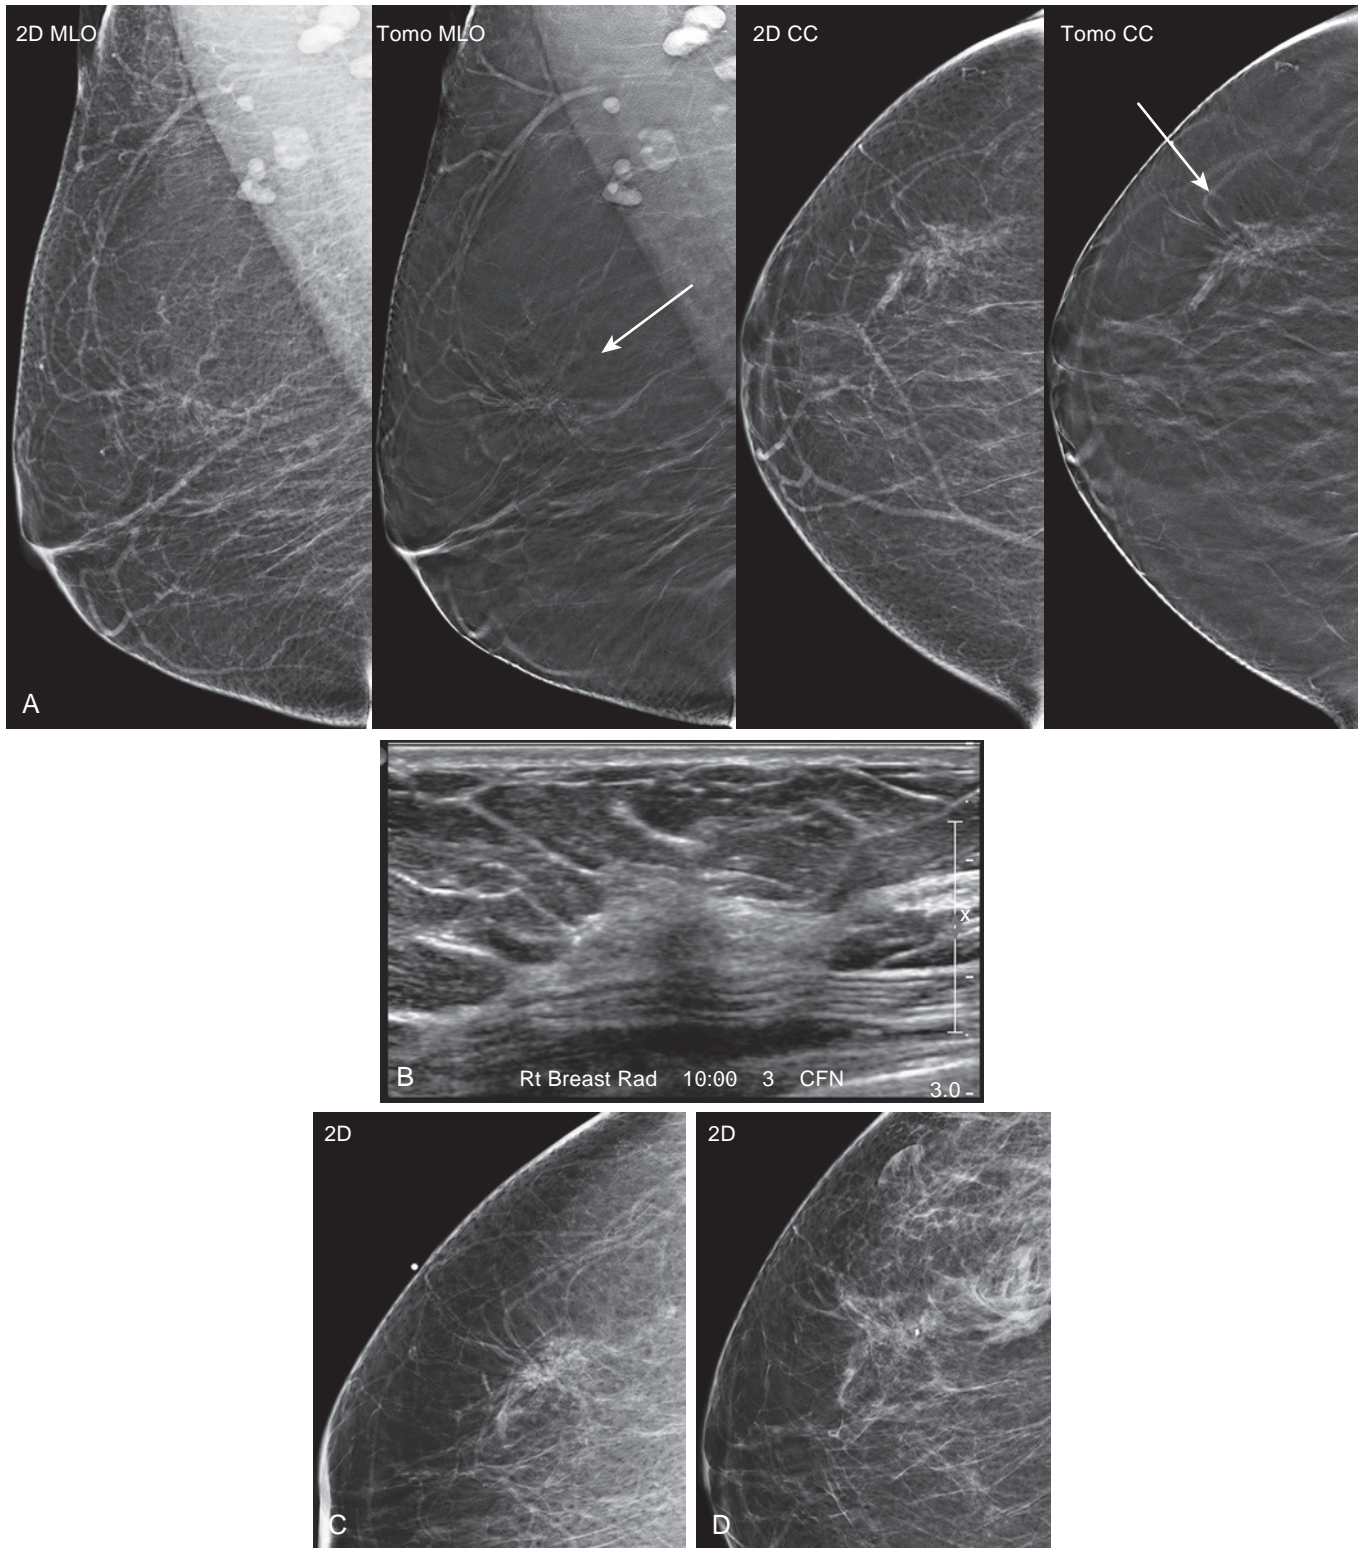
(A) A 50-year-old woman presented for screening mammography, which revealed architectural distortion in the upper-outer aspect of the right breast, best seen on the tomosynthesis slice images (*arrows*). (B) Targeted ultrasound reveals an ill-defined mixed echogenicity lesion in the upper-outer quadrant. (C and D) A BB was placed on the skin overlying the lesion, and mammographic views were repeated, which demonstrate the sonographic finding correlated with the mammographic finding. Ultrasound-guided biopsy demonstrated a complex sclerosing lesion and atypical ductal hyperplasia, confirmed with surgical excision.
